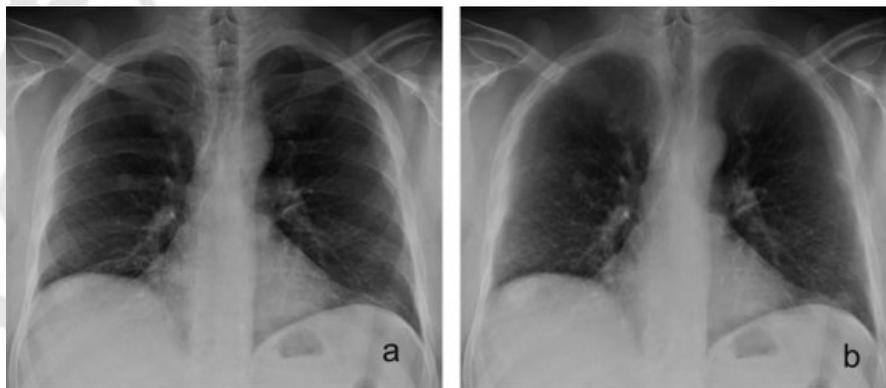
PA radiograph with a solitary nodule in the right lung. The nodule is overlapped by a projection of the seventh posterior rib. Digital bone suppression (Riverain Technologies, Miamisburg, OH) produces a bone suppressed image, where the rib is perfectly suppressed without suppressing the lung nodule. PA, posterioranterior.
